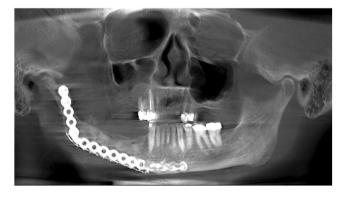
Radiograph of bone regeneration from a straight needle marrow aspiration device with modest mineral density Hu = 252.6
